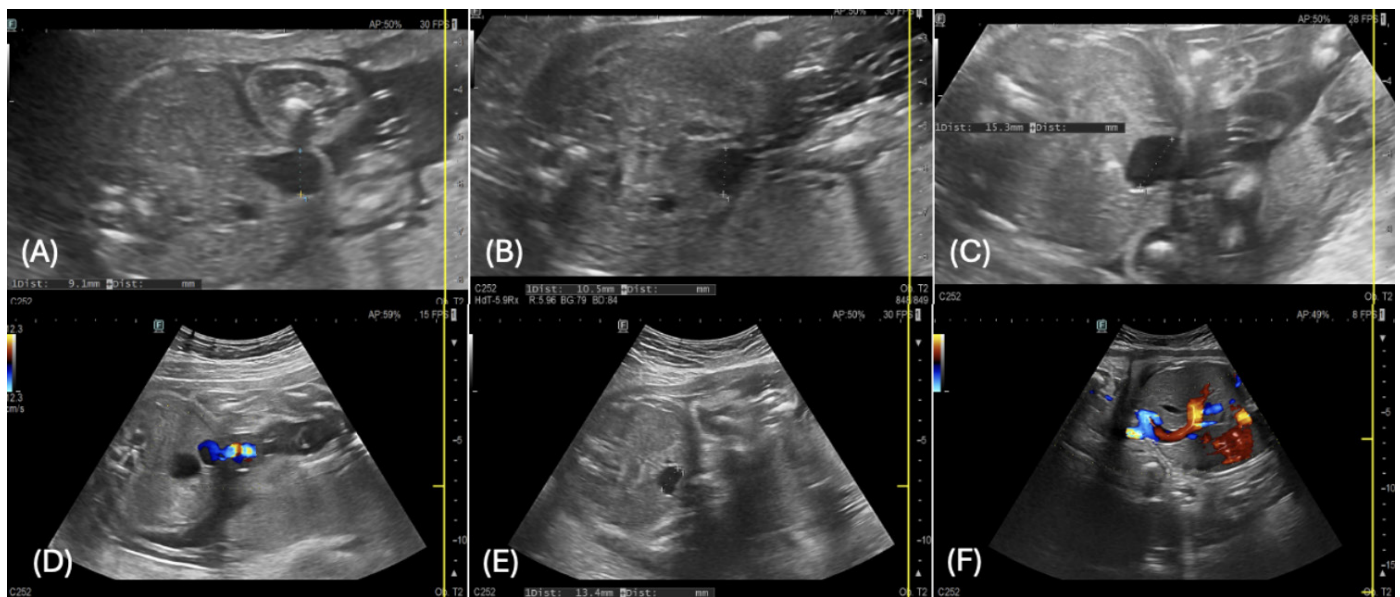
Ultrasonographic evaluation of intra-abdominal umbilical vein varix
